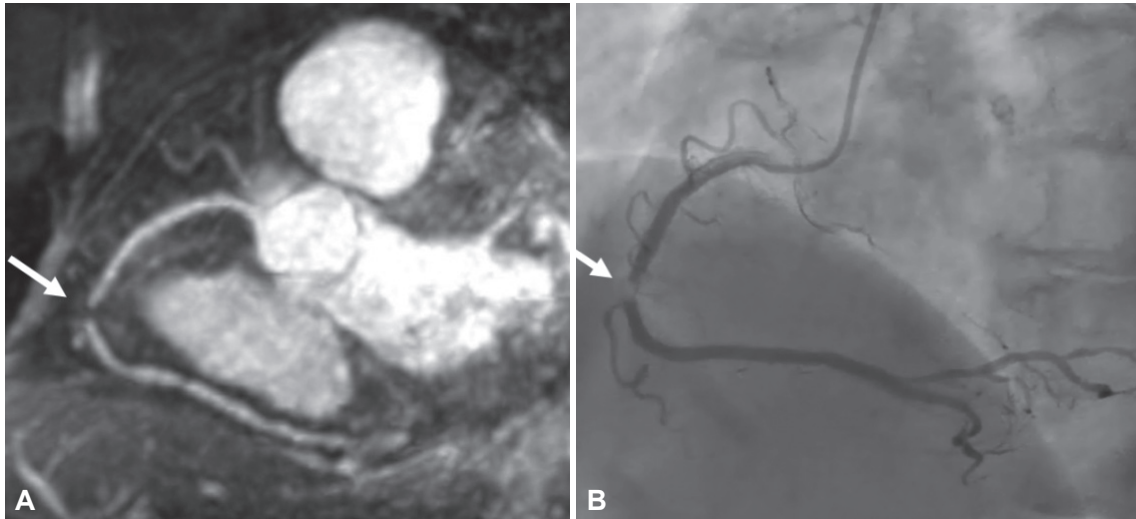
Maximum-intensity projection images of whole-heart coronary MRA in an 88-year-old female with significant mid-RCA stenosis (arrowed) (A) that was confirmed on X-ray coronary angiography (B). MRA: magnetic resonance angiography, RCA: right coronary artery.
